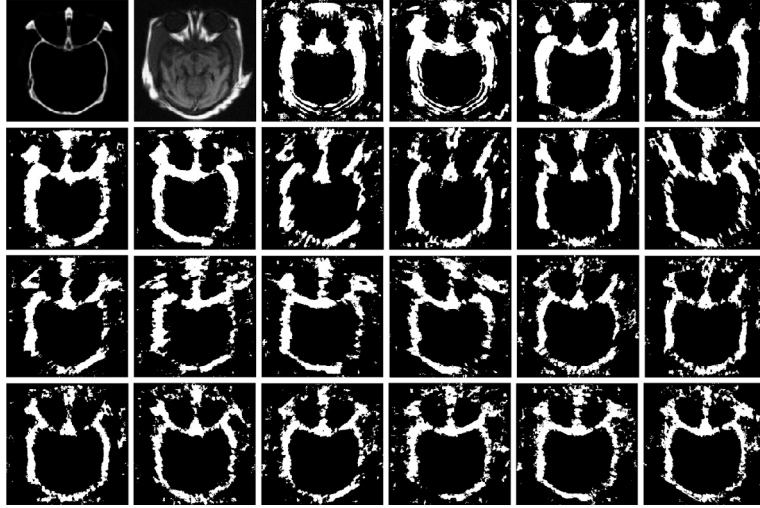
Activity levels of outputs P_A and P_B of the DTNP systems Π_A and Π_B on the high-frequency coefficient planes. The first two images correspond to the source CT and MRI images, and the other images represent the activity level images of the corresponding 22 high-frequency coefficient planes.
